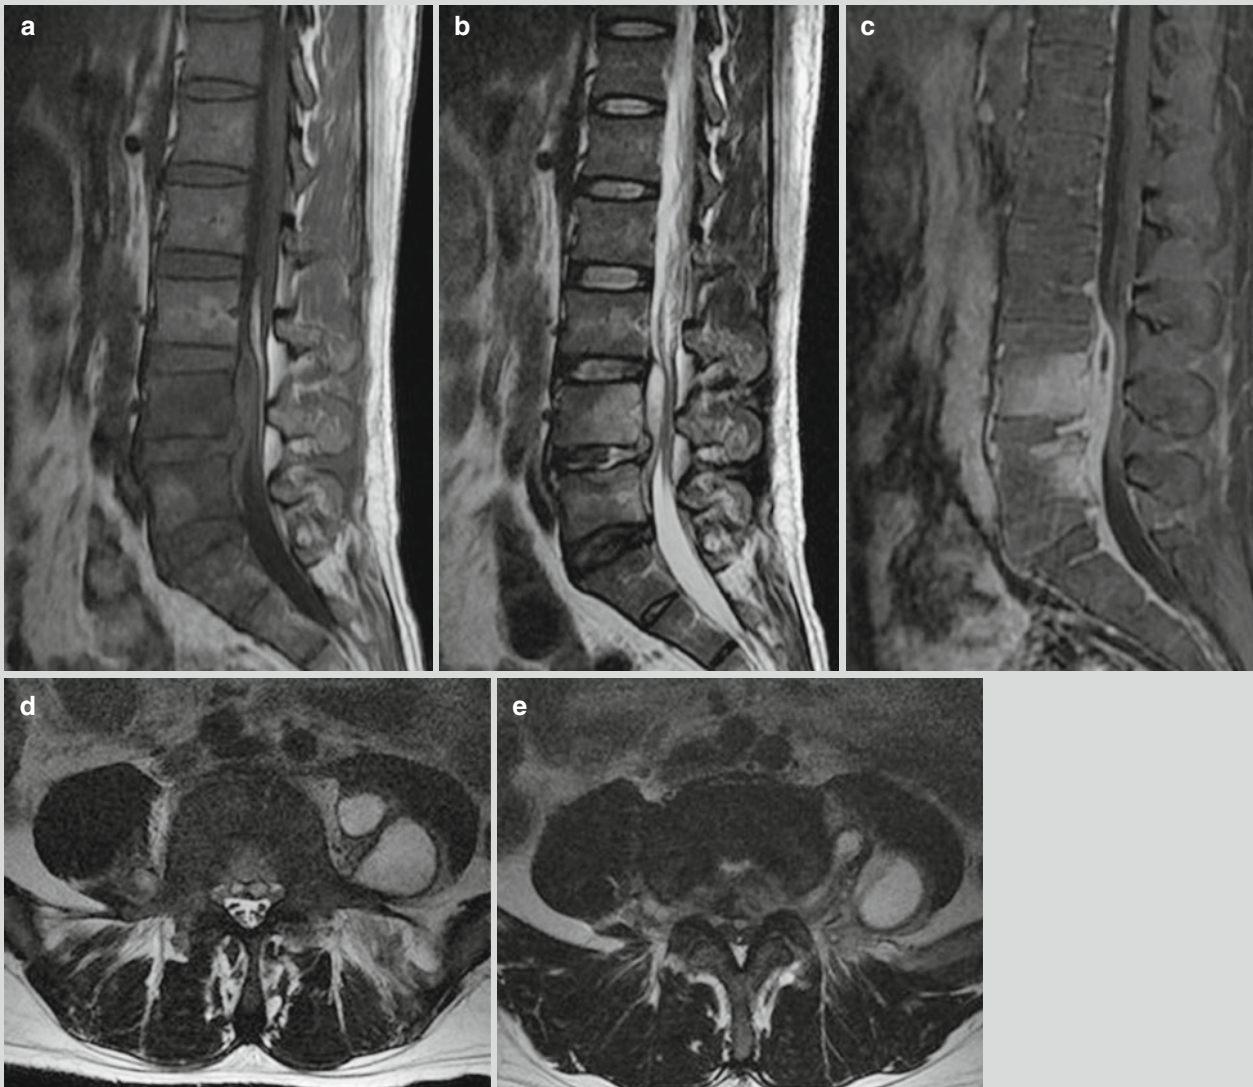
Brucellar spondylitis and paravertebral abscess. (a–e) MR imaging demonstrates vertebrae of L1–L5 with patches of long T1 and long T2 signals, with poorly defined boundaries. Intraspinous epidural abscess is demonstrated to connect with intervertebral disk
